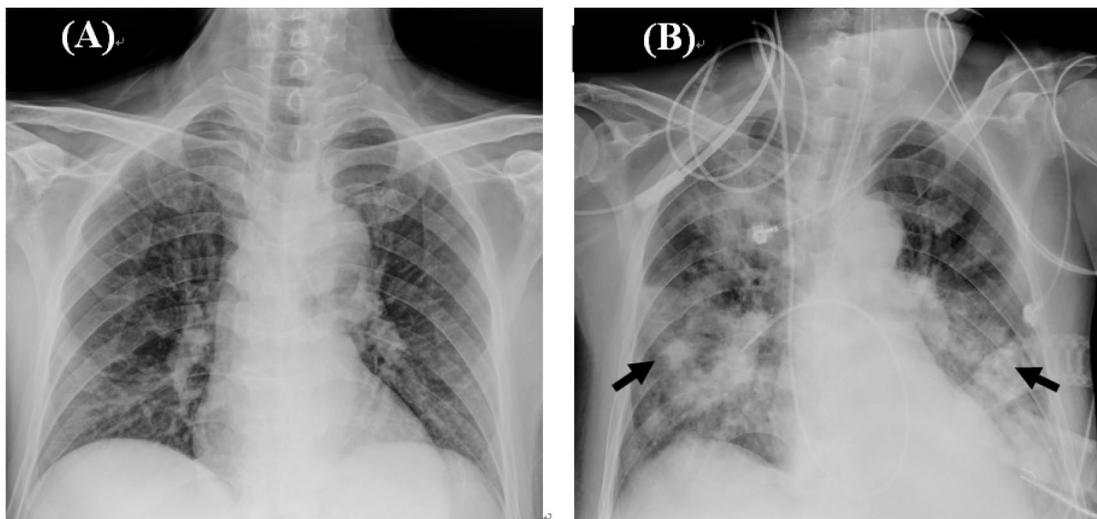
(A) Chest radiograph on day 1 of admission showing no abnormal infiltrates in the bilateral lungs. (B) Chest radiograph on day 8 of admission showing multiple alveolar and nodular infiltrates predominantly at the bilateral lower lungs (as arrows).
